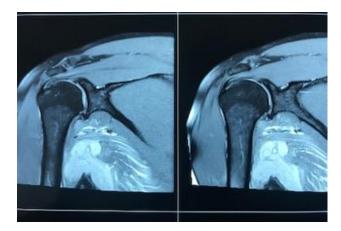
Shoulder MRI scan showing the torn teres major muscle.
